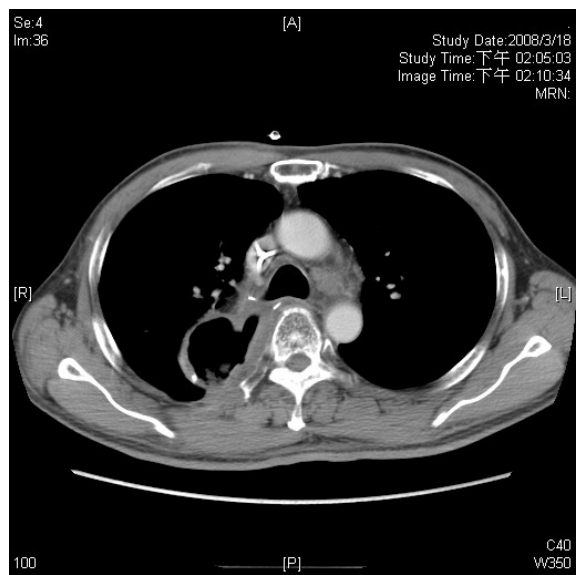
Chest CT, Post-OP
